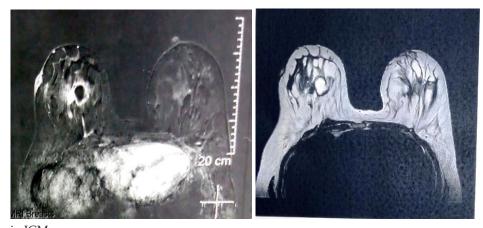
MRI finding in IGM
